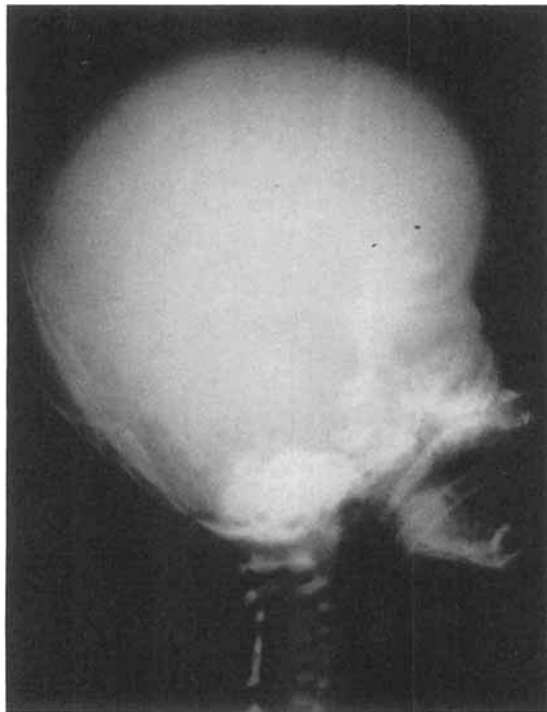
Radiograph of Apert newborn (at 31 weeks of gestation), showing coronal fusion with patent fissure superiorly.
